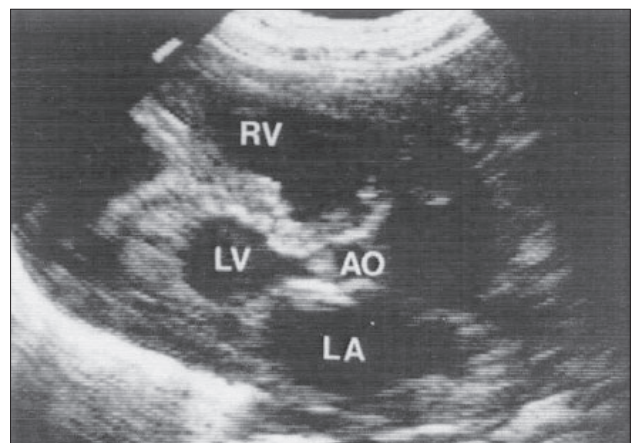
Echocardiography finding.
